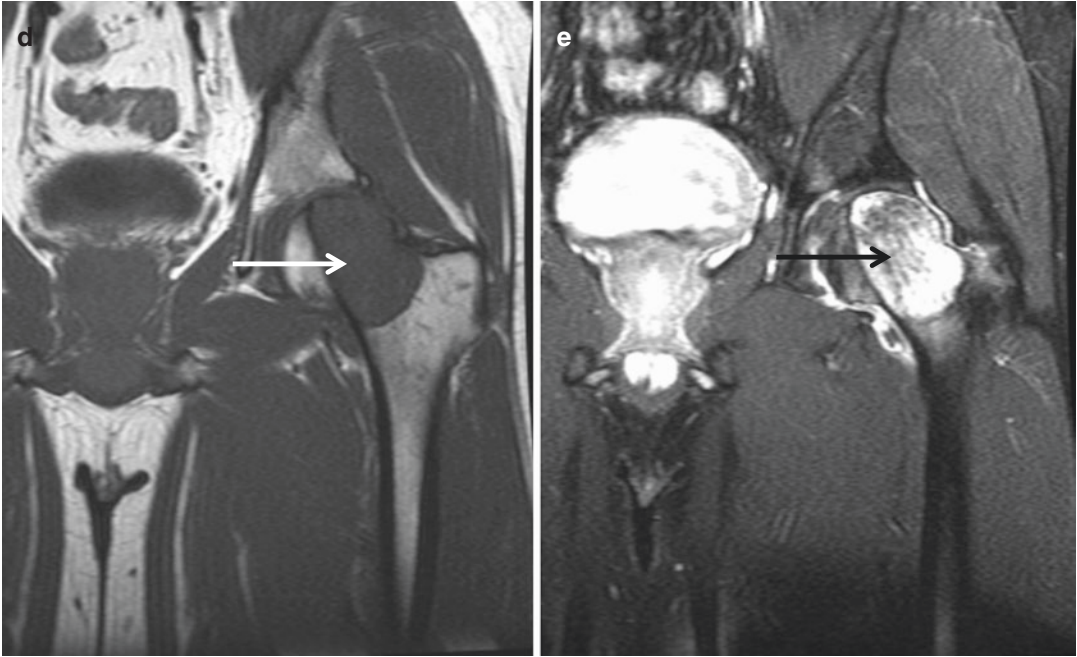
Clear cell chondrosarcoma. Anteroposterior radiograph of the right hip shows a well-defined osteolytic lesion (*arrow*) with no mineralization in the epiphyseal location of the proximal femur
